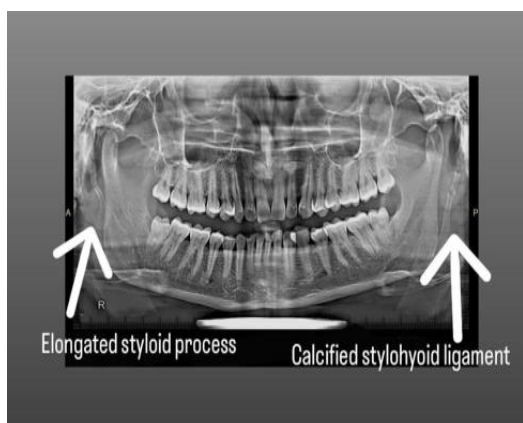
Patients X-ray with Eagles Syndrome
